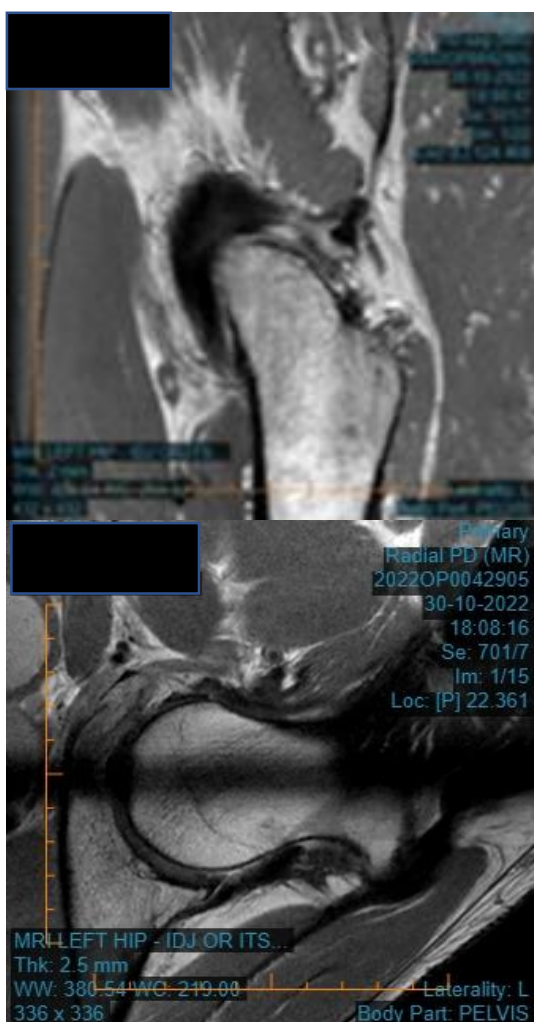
MRI data of the patient’s left hip.
